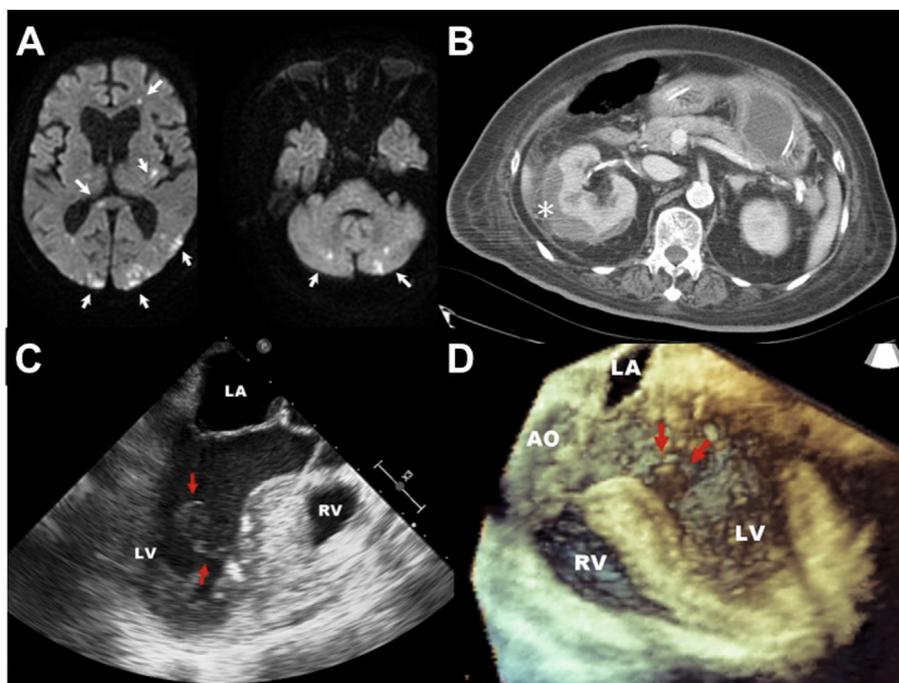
(A) Multiple acute infarcts in bilateral cerebral and cerebellar hemispheres (white arrows) on a diffusion-weighted magnetic resonance image of brain. (B) An enhanced computed tomography of abdomen demonstrated a right subcapsular renal abscess (asterisk). (C and D) A two- and three-dimensional transesophageal echocardiography showed an oscillating mass in left ventricle, with a stalk attached to the interventricular septum (red arrows). LA denotes left atrium; LV, left ventricle; RA, right atrium; RV, right ventricle; Ao, aorta.
